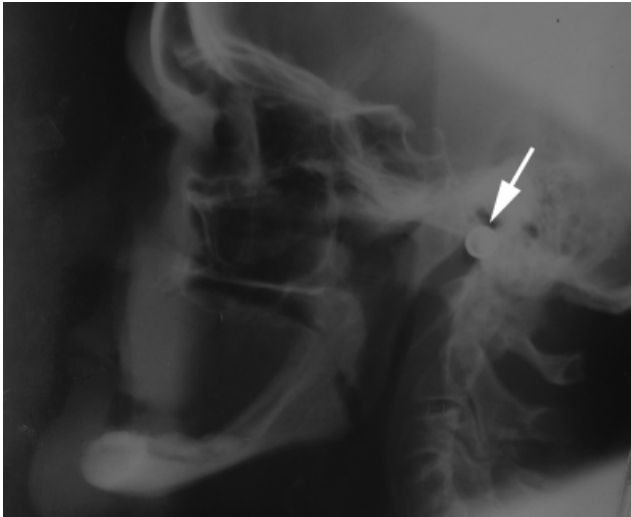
Example of a lateral cephalometric film. Note the head location piece arrowed; this ensures accurate repositioning should the patient require further radiographic views and may of use in postmortem film acquisition.
